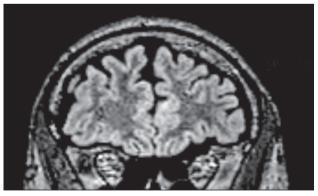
Pre-resection 1.5 T MRI, FLAIR sequence; coronal section at the level of the anterior cingulate cortex.
